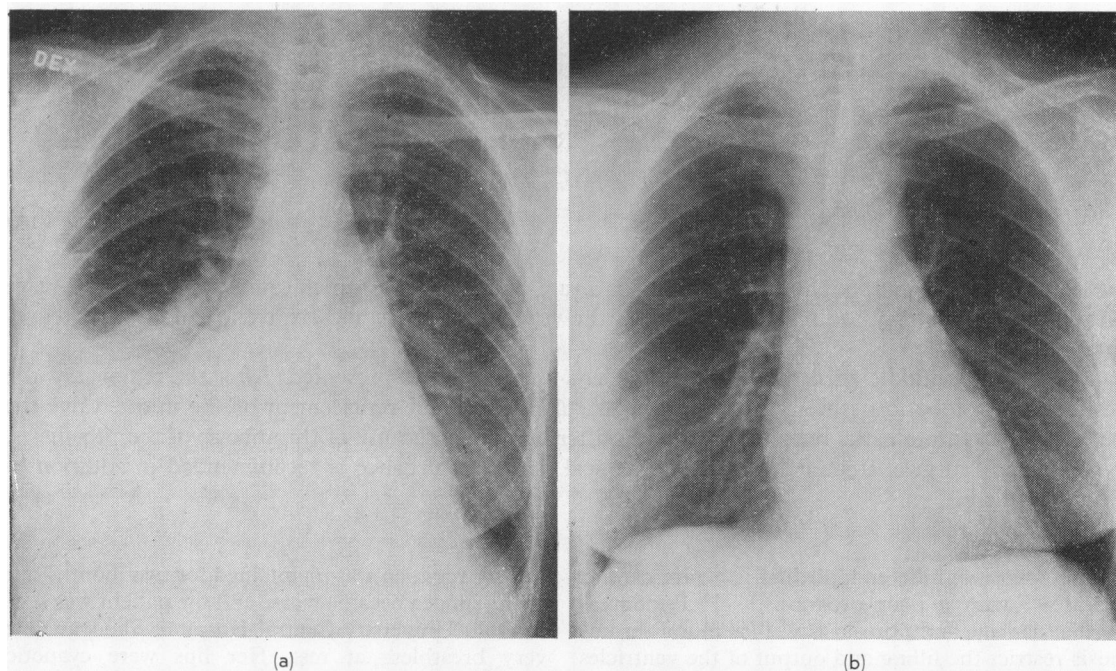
The anteroposterior chest x-ray film of the patient before operation (a). The heart size is normal, but the pulmonary veins are congested and a large right-sided pleural effusion is visible. After operation the chest x-ray film returned to normal (b).
